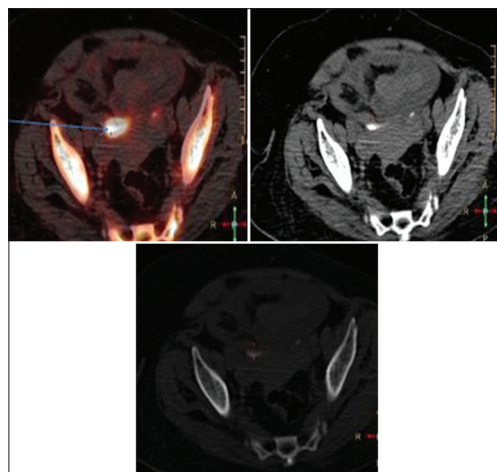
Axial positron emission tomography/computed tomography fused image shows increased tracer uptake corresponding to calcified soft tissue peritoneal metastasis
